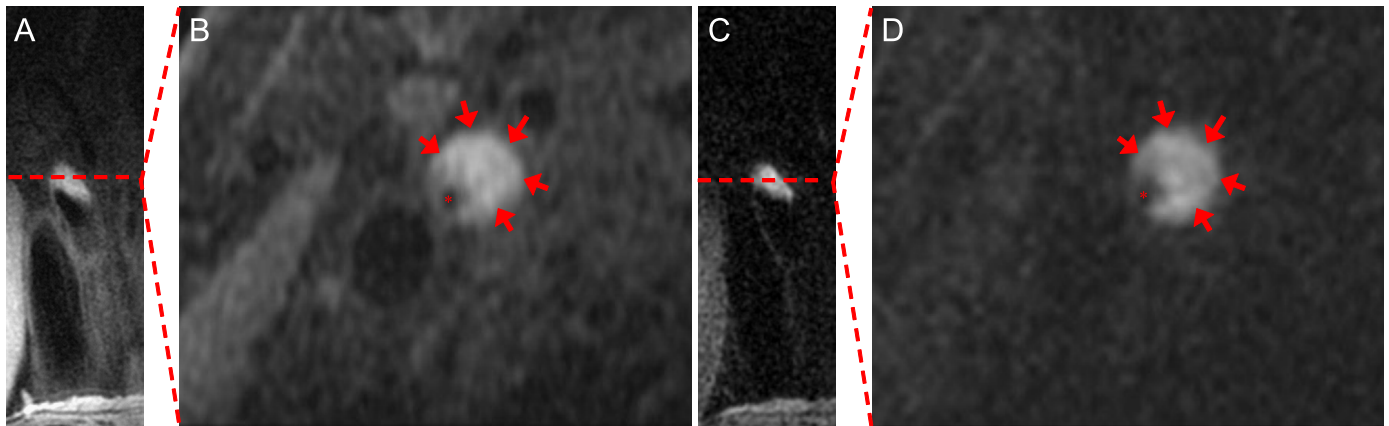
A large plaque hemorrhage depicted by MR imaging from a 72-year old asymptomatic patient (A) and (B) 3D-CUBE T_1 -weighted MR image in coronal and transverse planes; (C) and (D) direct thrombus image (DTI) at the same location in (A) in coronal and transverse planes; red asterisk: arterial lumen. (For interpretation of the references to color in this figure legend, the reader is referred to the web version of this article.)
